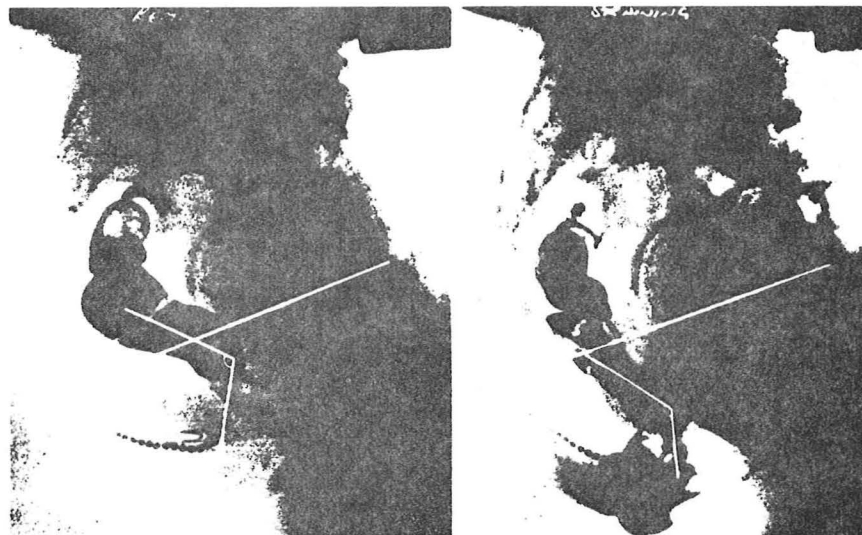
Lateral Radiographs of the Pelvis in a Patient with Perineal Descent at rest (left) and while straining (right). Note the obtuse rectoanal angle and its relation to the pubococcygeal line (From Bartolo et al, 1983b).
